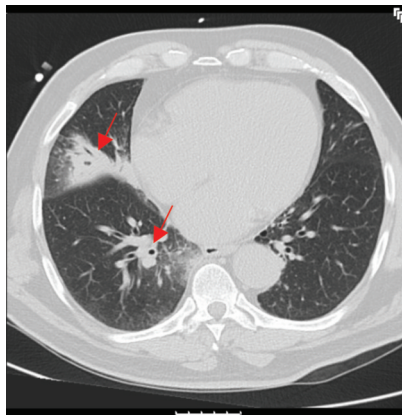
Thoracic CT scan showing abscesses in the right lung wall.
